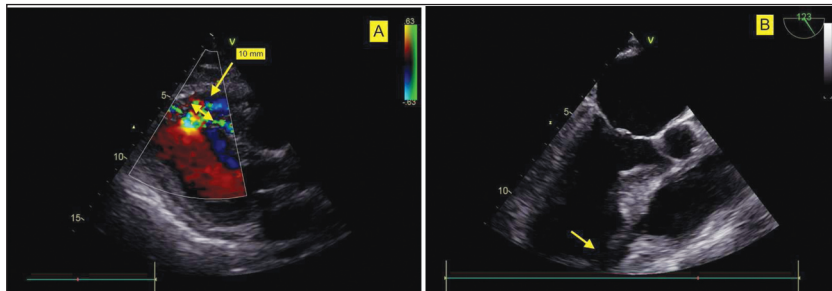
A-B) Transthoracic echocardiography 2D view of the post- myocardial infarction ventricular septal rupture with color Doppler.
